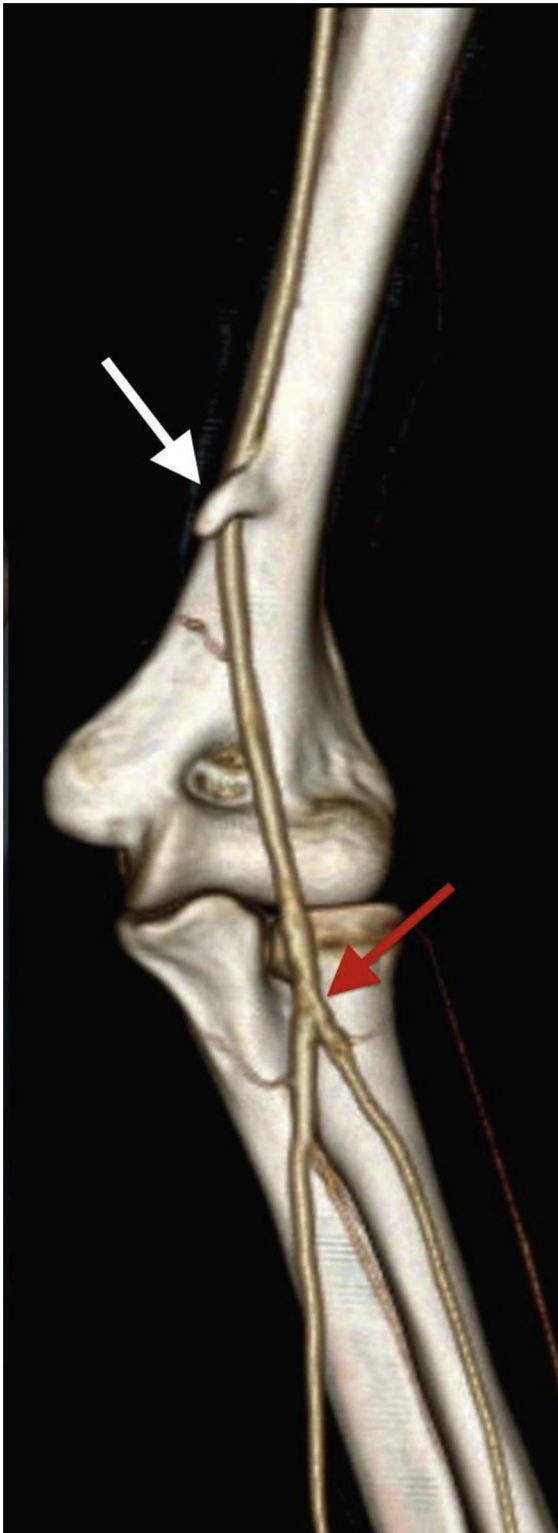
Three-dimensional reconstruction of a computed tomography angiogram of the left upper limb shows the hook-like supracondylar spur from humerus (*white arrow*). Distal thrombus in the brachial artery can be seen as irregularity in luminogram (*red arrow*).
